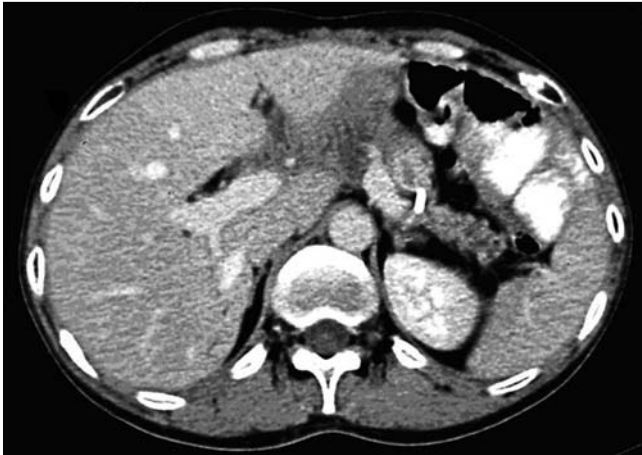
Computed tomography (CT) image showing no recurrence of the pancreatic duct dilatation after the EUS-guided pancreatic duct drainage.
